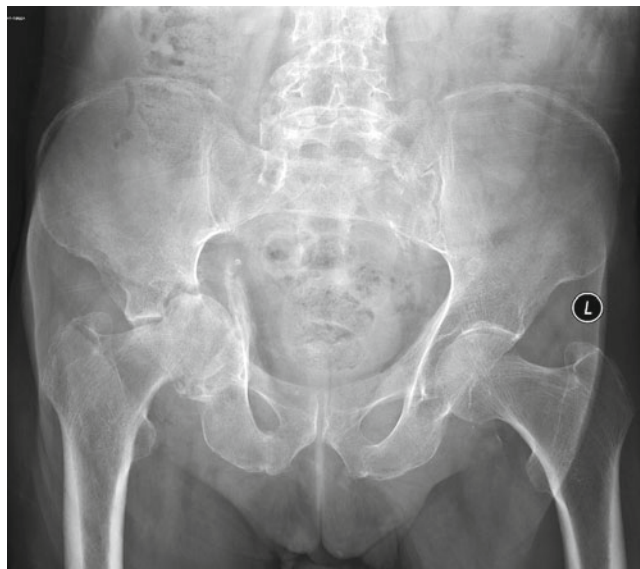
AP pelvis X-ray of a displaced right acetabular fracture
